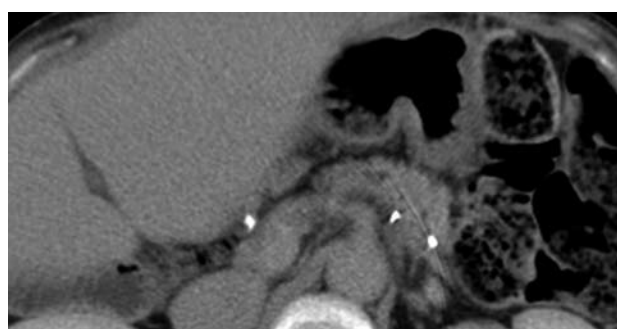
Computed tomography performed 2 d after removal of the drain in case 1 showing no fluid collection around the pancreas.
